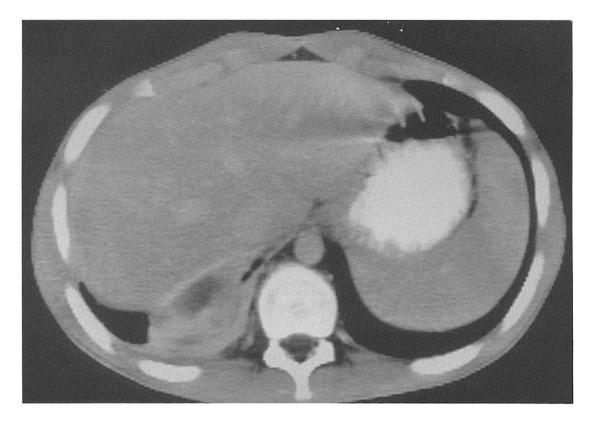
Computed tomography (CT) scan of a right adrenal primary neuroblastoma in an 18-month-old boy with opsoclonus myoclonus.
